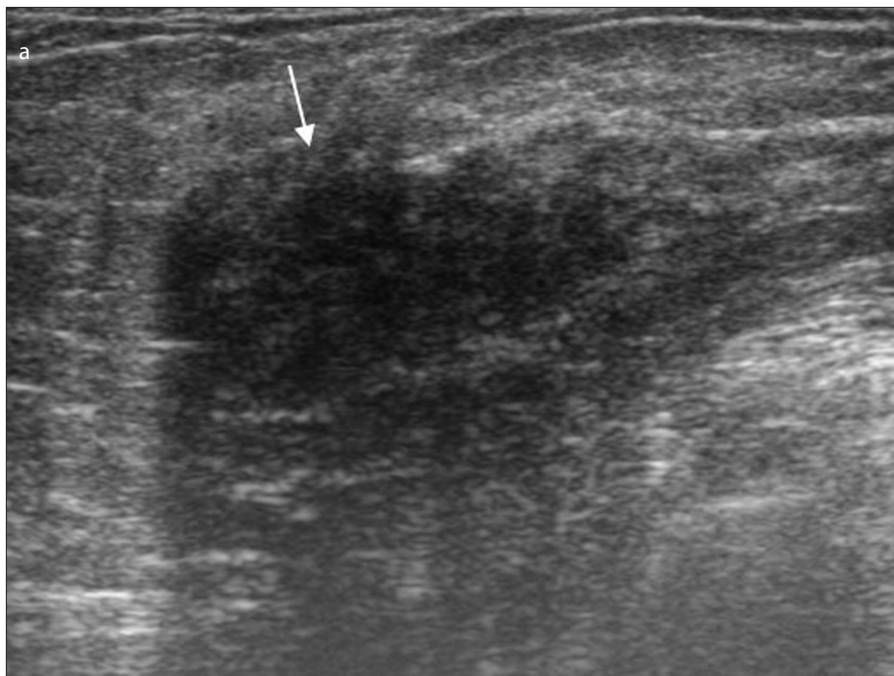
a–c. High-resolution ultrasound (HRUS) and CEDM images in a 44-year-old woman with equivocal left breast lump. HRUS image (a) shows non-circumscribed heterogeneous hypoechoic area (2.8×1.6 cm) in left upper outer quadrant. Low-energy CC and MLO views of both breasts in panel (b) show bilateral symmetrical retroareolar dense breast (arrowhead) and focal asymmetric density in left upper outer quadrant (arrow) corresponding to the US findings. Contrast image (c) shows no enhancement of the asymmetric density noted in (a). Subsequently, ultrasound-guided biopsy of the left breast lump yielded fibroadenosis.
